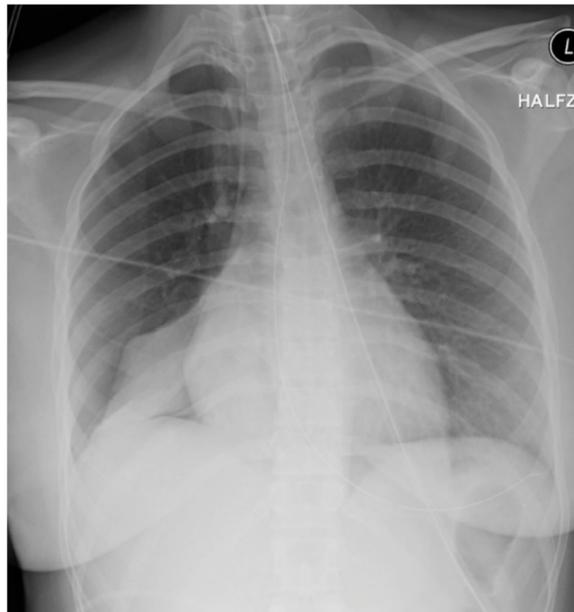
Chest X-ray 1 hour and 30 minutes after extubation (14:51 PM); atelectasis of the right lower lobe.
